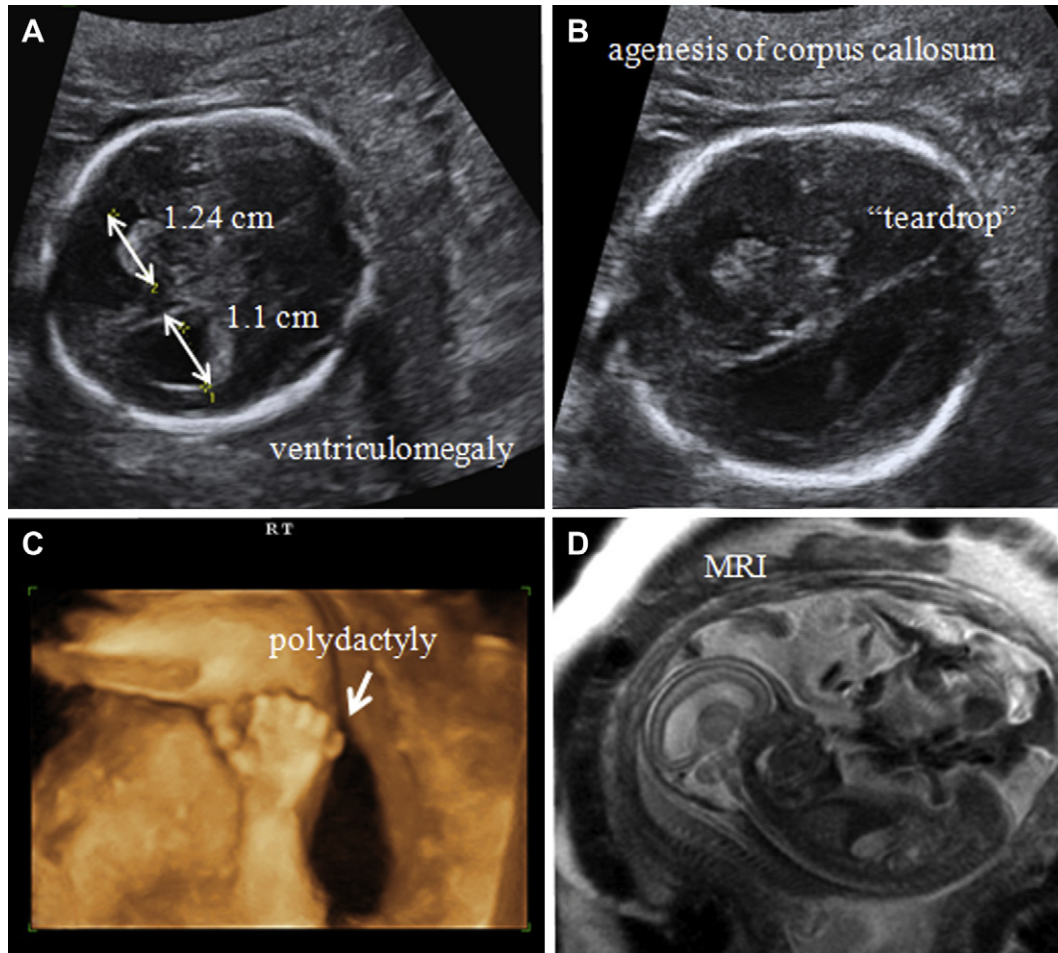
Ultrasound showed ventriculomegaly, agenesis of corpus callosum and polydactyly (A–C). Magnetic Resonance Imagin presented ventriculomegaly (D).
